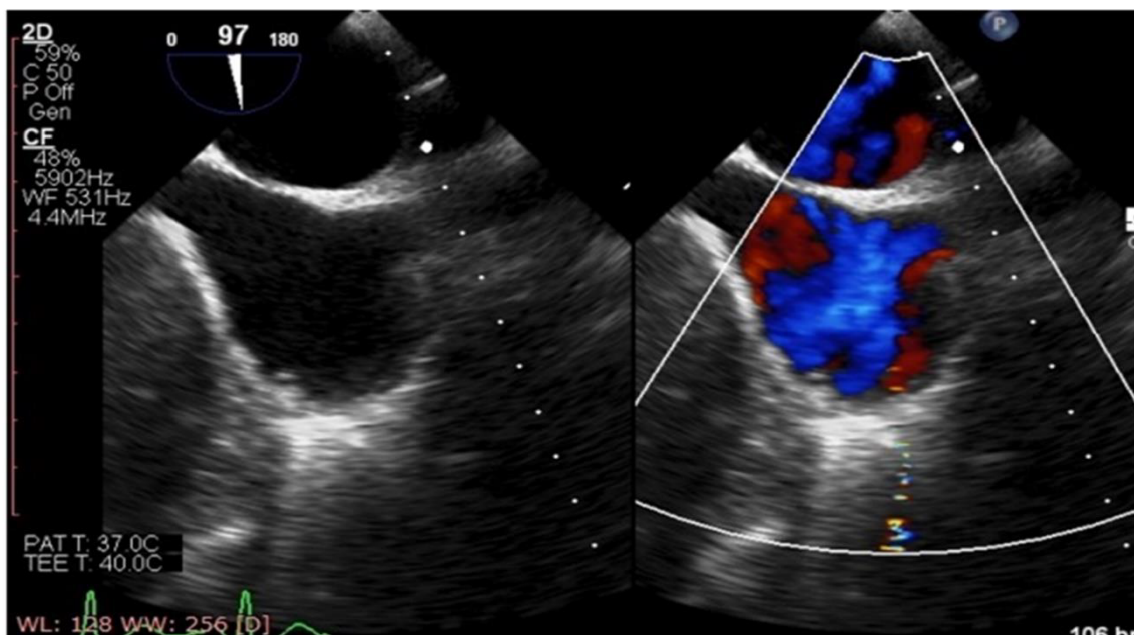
Transesophageal echocardiography showing no vegetation or shunt.
